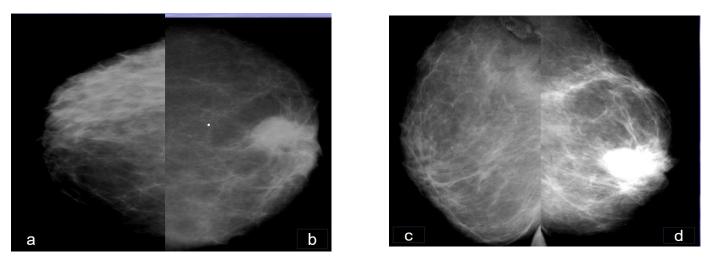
Bilateral mammogram x-rayed from the front (a), right external oblique (b), left side and left external oblique (d): shows a left retroareolar mass, of high density, irregular shape and contours, without microcalcification within it
